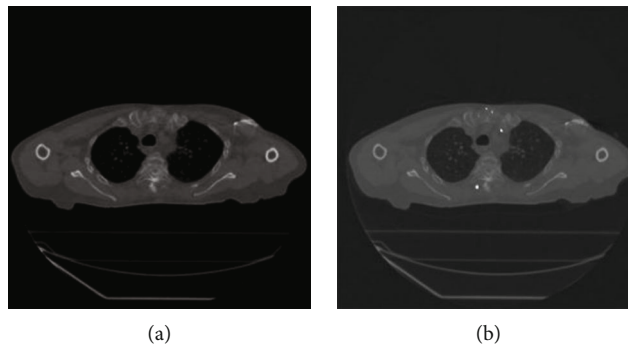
Corrected CT image and fused CT image.
